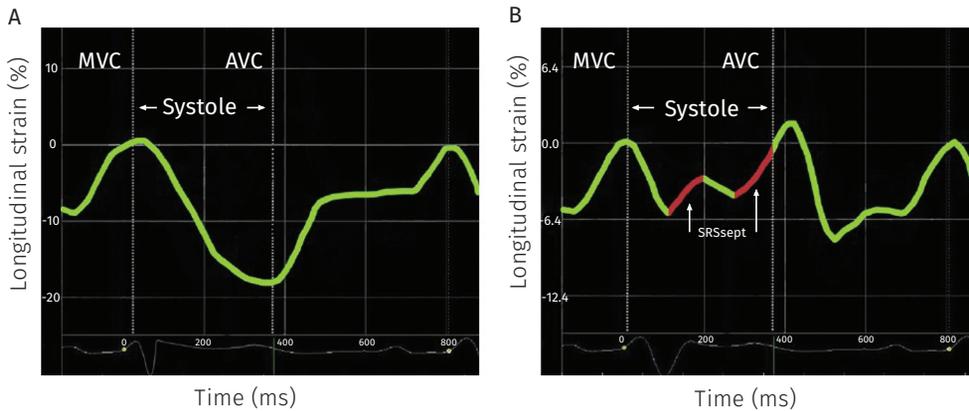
Longitudinal speckle tracking traces of the septal wall derived from echocardiographic 2D gray-scale images. When the speckle tracking trace is directed downwards the septal wall shortens. When the speckle tracking trace is directed upwards the septal wall stretches. Systole is defined as the time period between mitral valve closure (MVC; first dotted vertical line) and aortic valve closure (AVC; second dotted vertical line). Panel A: Trace of the septal wall demonstrating a normal septal curve. Panel B: Trace of the septal wall demonstrating systolic rebound stretch of the septum (SRSsept). SRSsept is indicated by the red lines in panel B. Systolic rebound stretch of the septum: Cumulative amount of systolic lengthening of the septum after initial shortening. In this example SRSsept is $3.0 + 4.0\% = 7.0\%$.
